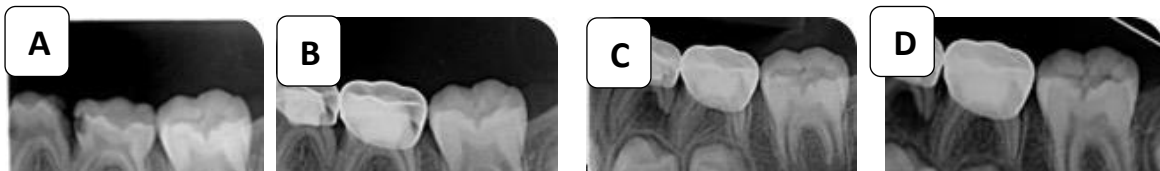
Periapical radiographs of MTA case; A: Pre-operative radiograph, B: Immediate postoperative radiograph, C: After 6 months, radiograph, and D: After 12 months radiograph.
